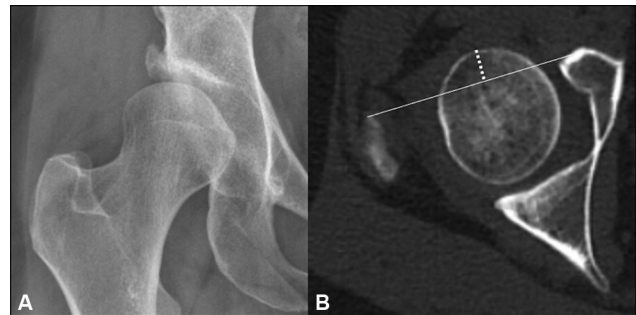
Anteroposterior radiographs of the right hip (A) of dysplastic hips with increased Tönnis angle with corresponding computed tomography (B) showing increased femoral offset.
